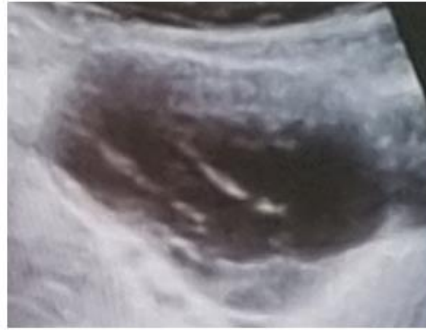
Pelvic ultrasound examination revealed an enlarged pelvic mass 6,5cm, septated, right ovarian cyst with echogenic contents.
